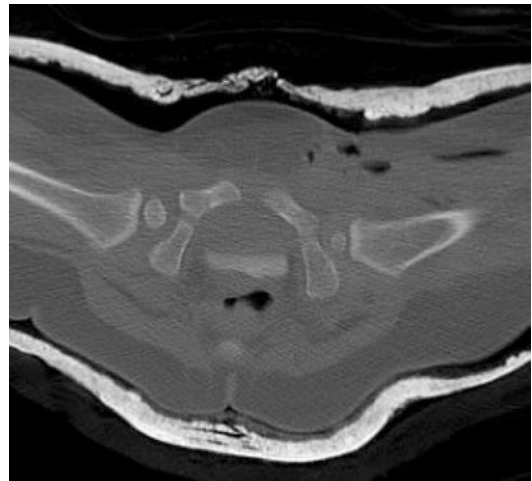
Single cut CT after open reduction of left hip. Note thinly padded and expertly molded (dorsum of greater trochanter) plaster spica cast to maintain position after open reduction
